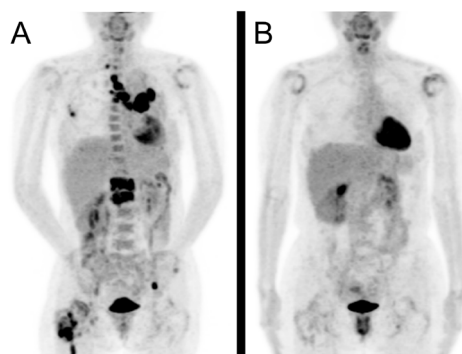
Positron emission tomography-CT before treatment (A) and 4 months after treatment (B) with nivolumab. The primary tumour as well as metastases to the lymph nodes and spine seen before treatment almost completely disappeared. On the other hand, active inflammation was detected in the shoulder joints bilaterally (B).
